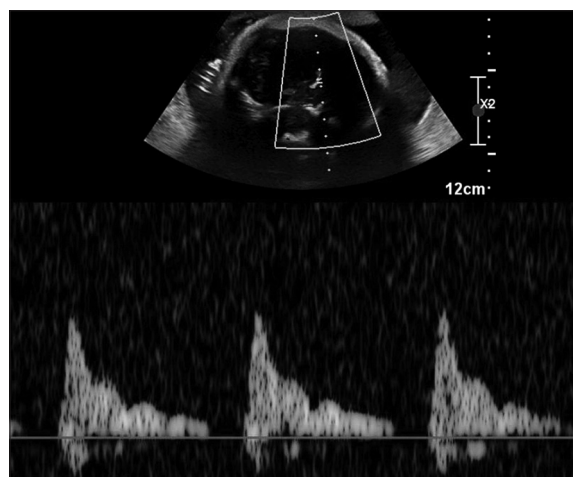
Abnormal middle cerebral artery Doppler profile with absent end-diastolic flow
